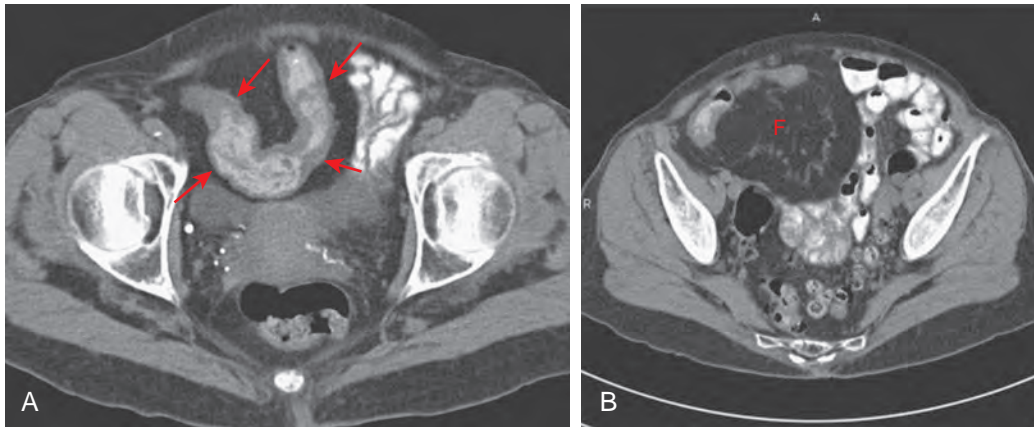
Crohn's disease. A. This enhanced CT scan shows circumferential mural thickening of the terminal ileum (arrows). B. A more cephalad image shows associated fibrofatty proliferation (F) of the mesentery.
